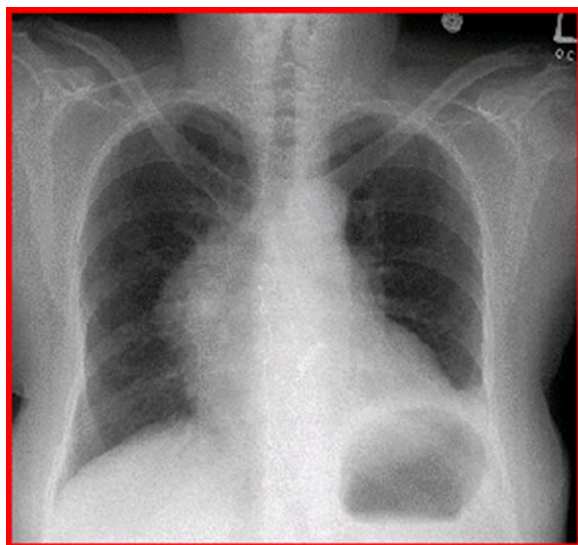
Preoperative posteroanterior chest X-ray.
